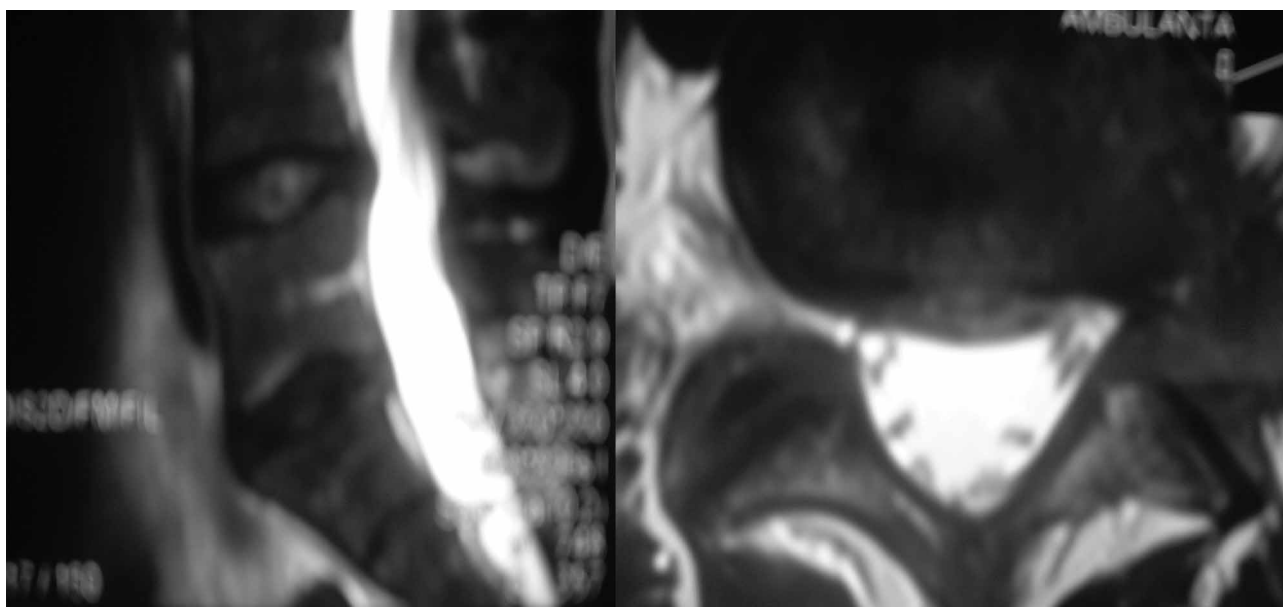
MRI shows spontaneous regression, with intact intervertebral segment.
